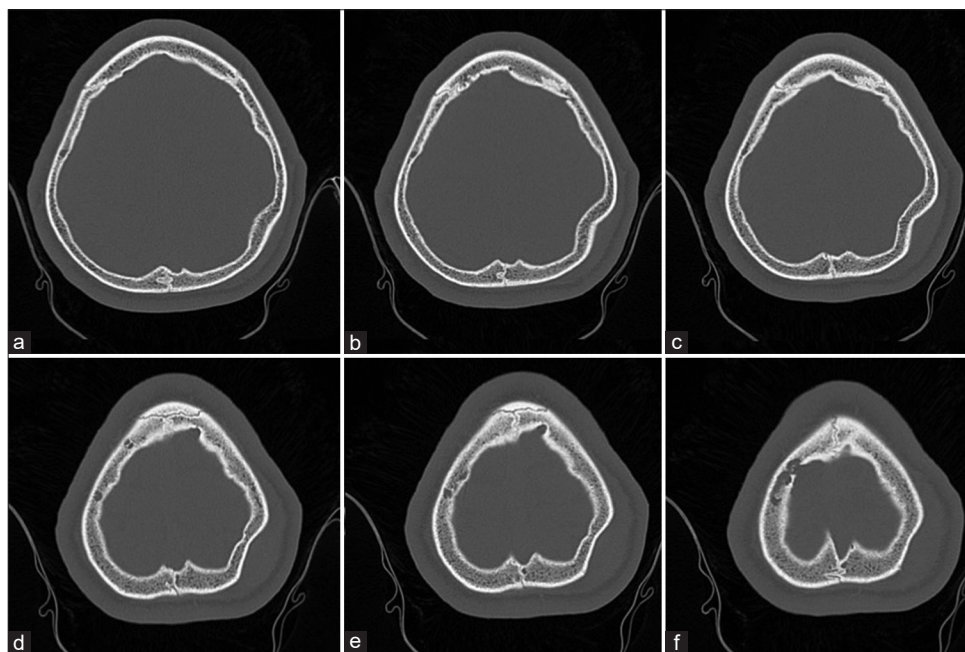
(a-f) Computed tomography scan bone window where we observe a depressed “ping-pong” fracture in the left parietal bone.
